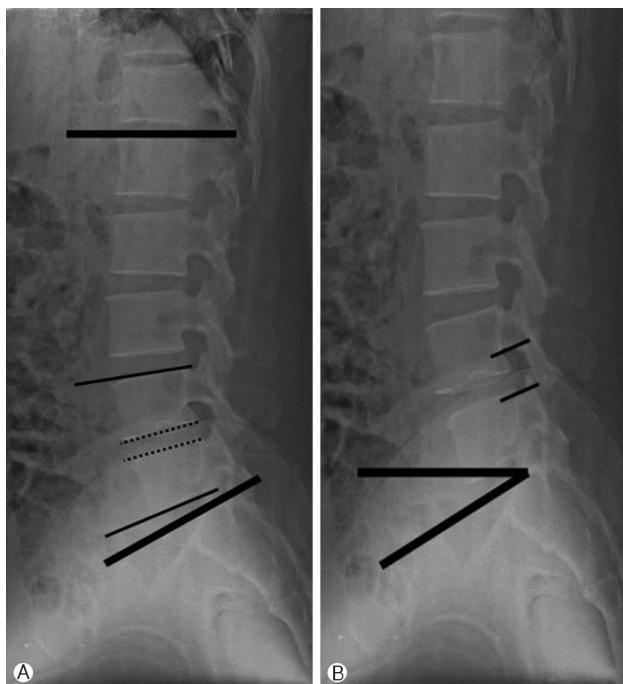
The radiographic parameters.
